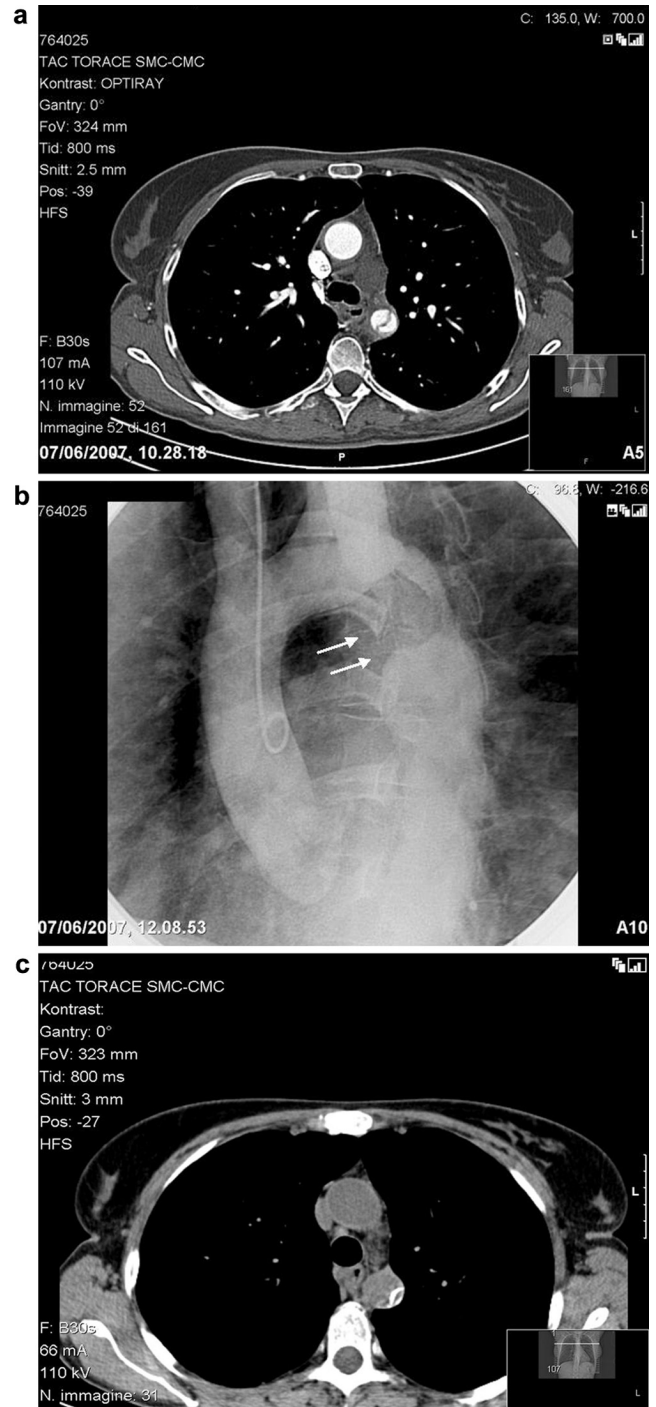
(a) Chest CT-scan showing the dissection of the isthmus. There is no thrombosis in the external lumen. (b) Direct examination without contrast enhancement. The collapsed prosthesis at distal anastomosis is clearly visible. (c) Angiographic view of the collapse of the interposition graft.
